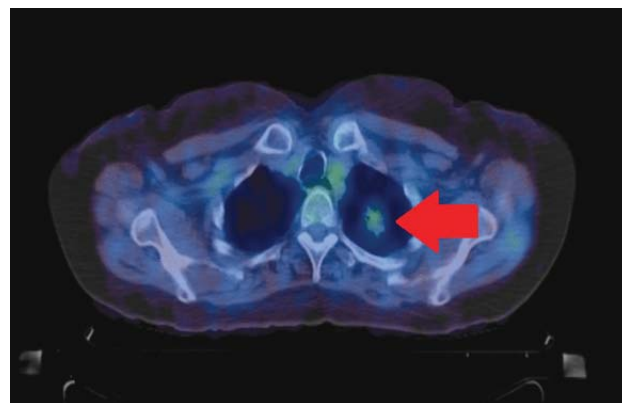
Axial fused PET/CT show mildly hypermetabolic pulmonary nodule in the left upper lobe peripherally intense right vocal cord uptake
